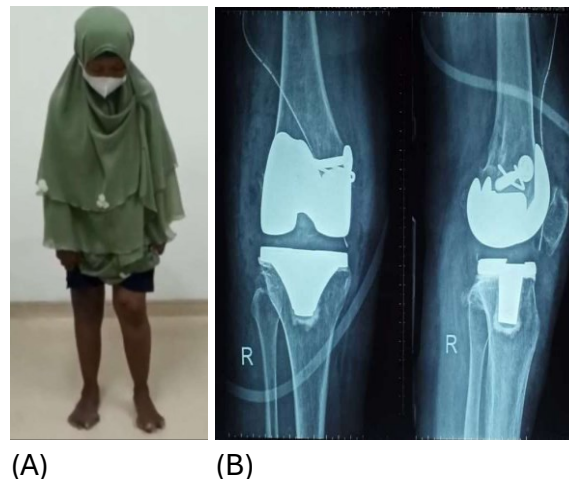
post operative right knee with painless, stable and corrected valgus deformity A. Alignment view, B. X-ray view.
